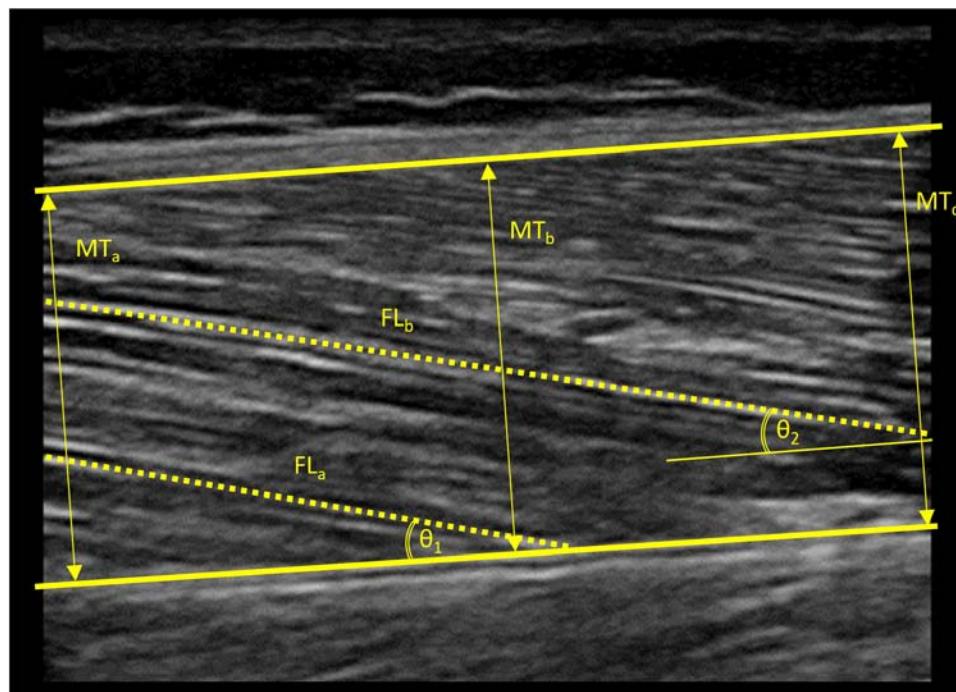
Ultrasound image obtained from the vastus lateralis muscle of a standard subject. Thick lines indicate the superior and inferior aponeuroses of the vastus lateralis muscle. Arrows indicate the three different points at which muscle thickness was measured. Dashed lines indicate the visible portions of muscle fascicles. Arched lines indicate angles formed between the visible muscle fascicles and the inferior aponeurosis. Non-visible portions of muscle fascicles were estimated using a linear extrapolation of fibers and aponeuroses in order to estimate fascicle length. MT, muscle thickness; FL, fascicle length; θ, pennation angle.
